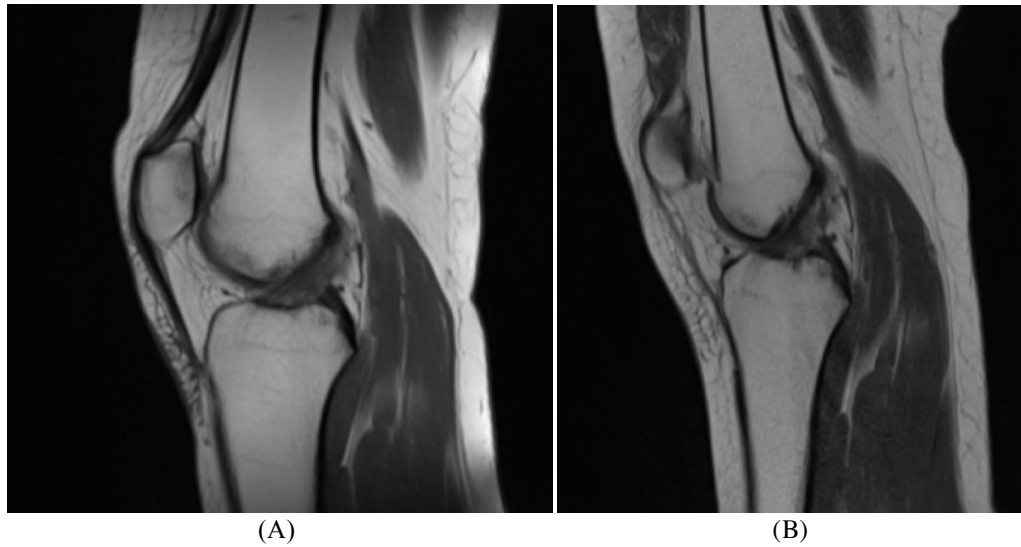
Sagittal Image of Knee MRI using : (A) Volume Coil (B)Surface Coil
